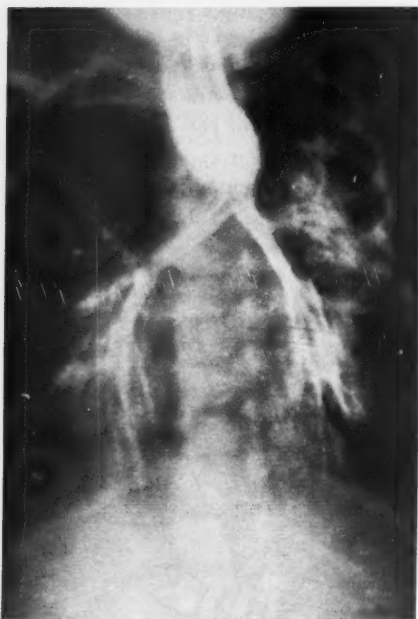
X-ray of twin B. Dye was placed in the esophagus and immediately passed through a recurrent tracheo-esophageal fistula into the trachea and bronchi. Notice that no dye has passed through a very tight stricture into the distal esophagus.
